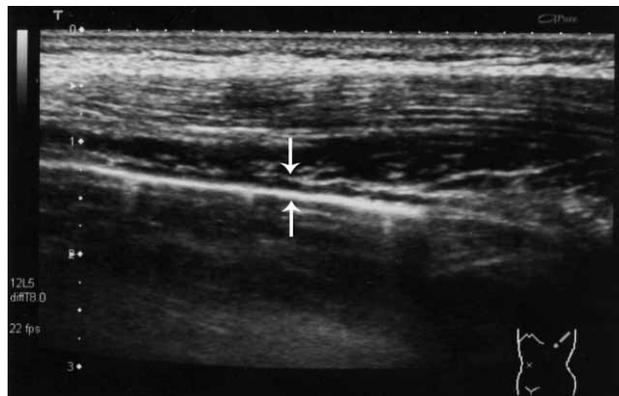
Ultrasonographic image of normal left pleural space with no fluid in between the pleurae (white arrows). The patient was examined in »leaning on the elbow position«, 12 MHz transducer was used.
